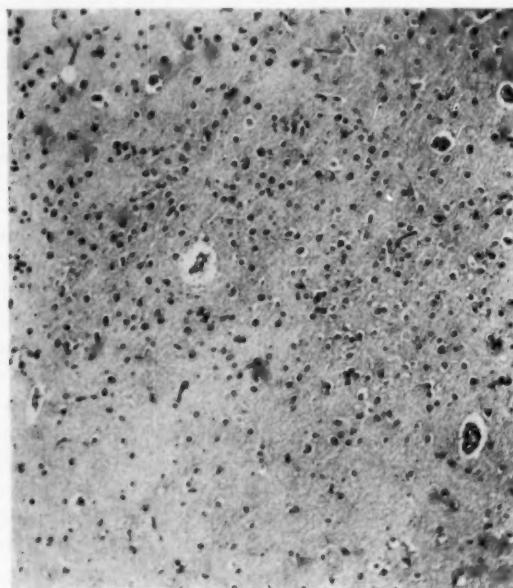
Human prefrontal cortex. An ultrasonic beam of 7 watts per square centimeter at 1,000 kc. per second, directed from above, had passed through this section taken from the bottom of a parasagittal sulcus. The ganglion cells have disappeared. No gross necrosis seen in this brain. Autopsy two months after irradiation. Magnification, $\times 160$.
